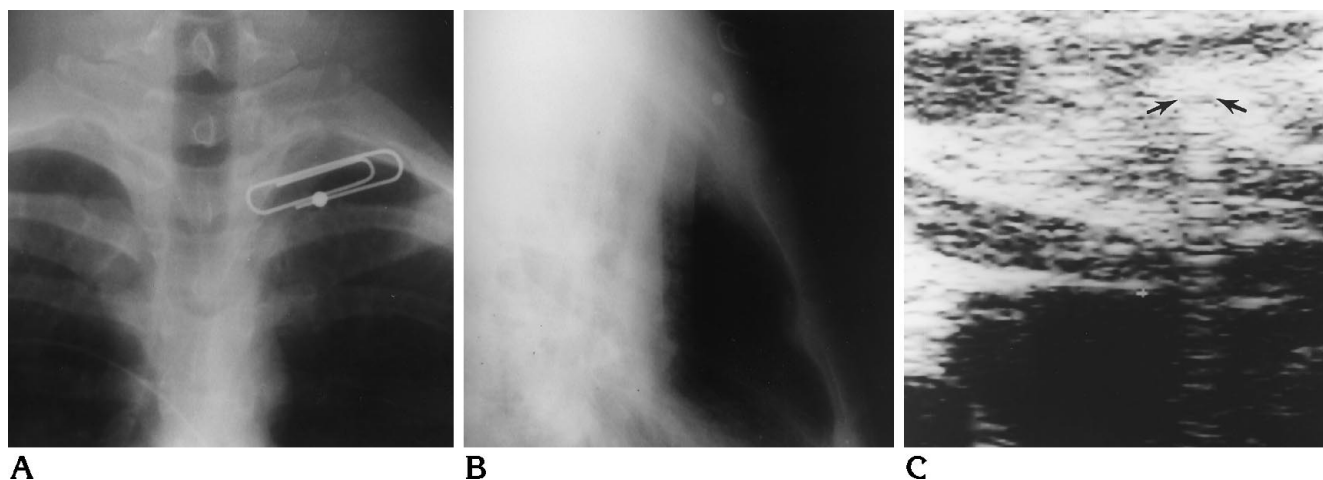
Posteroanterior (A) and lateral (B) chest radiographs show a BB in the soft tissues of the anterior part of the neck. C, Transverse gray-scale sonogram at the level of the proximal portion of the common carotid artery (CCA). Hyperechoic interface (arrows) with reverberation artifact representing the pellet is clearly seen in the soft tissues anterior to the intact and patent CCA. The patient refused angiography.
